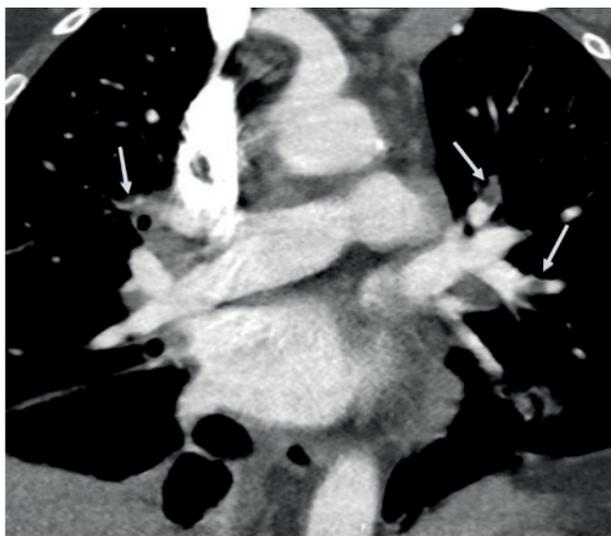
Contrast-enhanced pulmonary CT angiography shows filling defects compatible with thromboembolism in the segmental branches of both pulmonary arteries in the upper lobes and in the left lower lobe branch (arrows).
